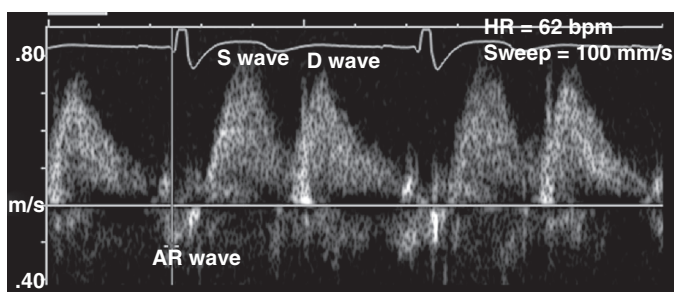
■ Normal pulmonary venous flow profile as measured by transthoracic pulsed wave Doppler with the sample volume placed in the right superior pulmonary vein. It is characterized by a predominant systolic wave (S), a diastolic wave (D), and an atrial wave (AR) (from reversal of flow into the pulmonary veins occurring during atrial contraction). The pulmonary venous flow profile always should be interpreted in conjunction with the transmitral Doppler pattern to have a more complete assessment of diastolic function.
